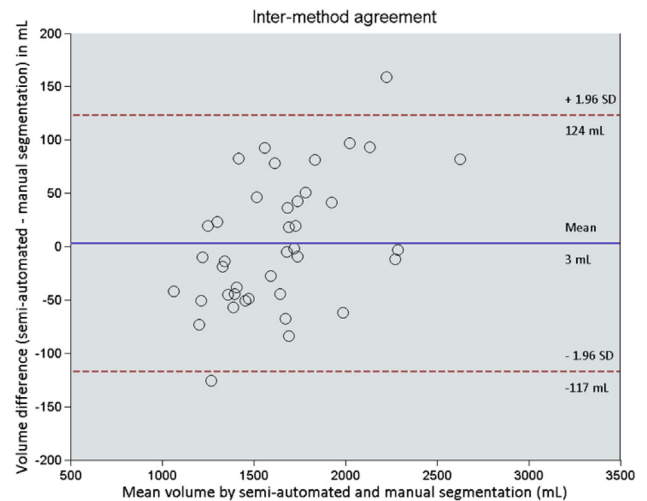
Bland-Altman plot of the volume difference between semiautomated and manual segmentation of computed tomography images and the mean volume (reader 1 vs. reader 4). Mean difference was demonstrated with solid line and 95% limits of agreement with dashed lines.
